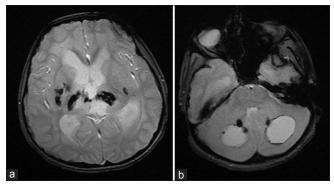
(a and b) magnetic resonance imaging shows blooming in bilateral Basal Ganglia, Thalami and Dentate nuclei on gradient echo images suggesting calcification
